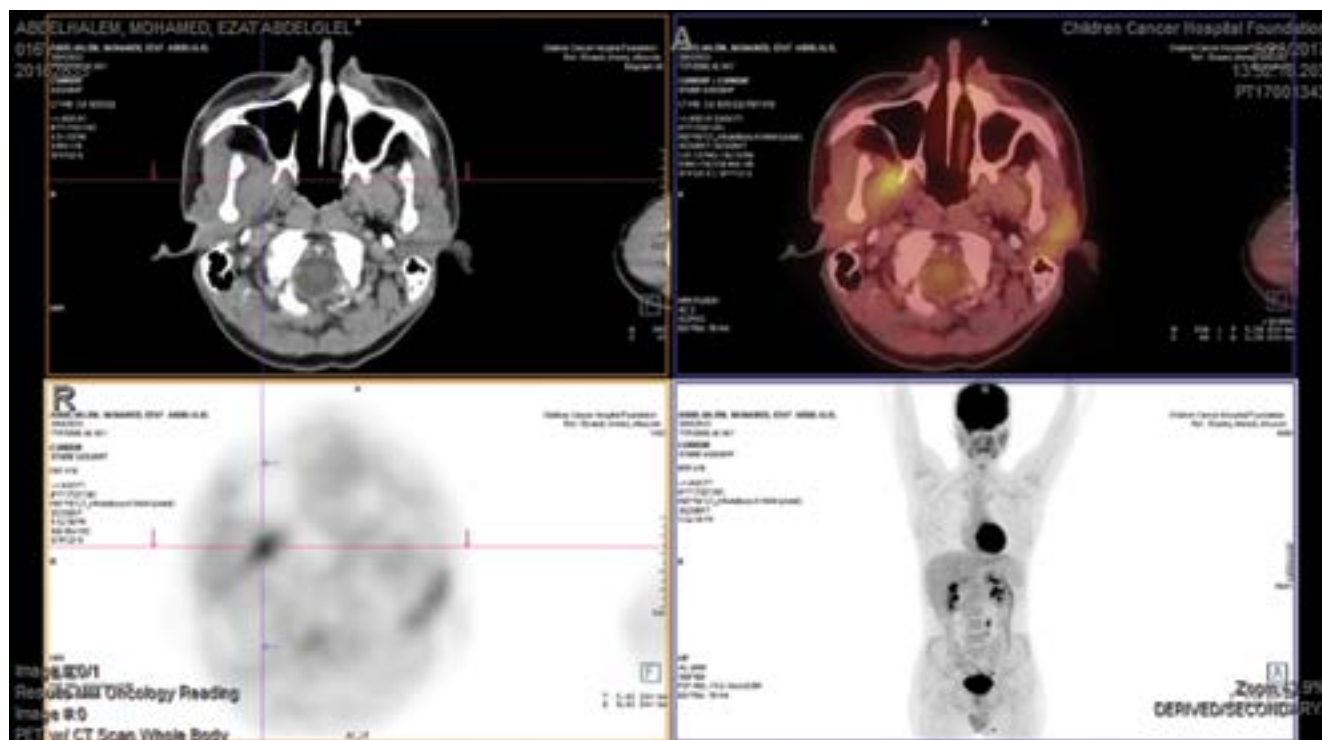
Axial and MIP images of PET/CT and fused ¹⁸F-FDG-PET/CT images of the same patient's post induction phase showing partial response of the mandibular lesion SUVmax 4, the patient was scored according to 5-p-s as score 4
